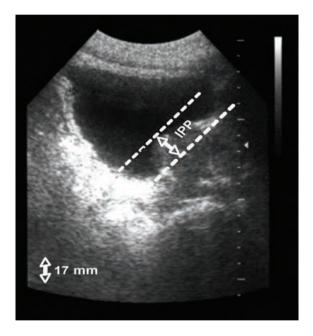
Transabdominal ultrasound imaging of the urinary bladder in longitudinal direction to visualize a prostate median lobe growing inside the bladder lumen. The distance between bladder neck and the tip of the prostate median lobe is known as intravesical prostatic protrusion (IPP). The IPP distance of this individual patient is 17 mm (IPP-grade 3).
